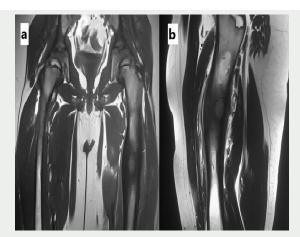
Magnetic resonance imaging demonstrating multiple juxta-cortical microabscesses in addition to the intra-medullary lesion, raising suspicion of infection.
